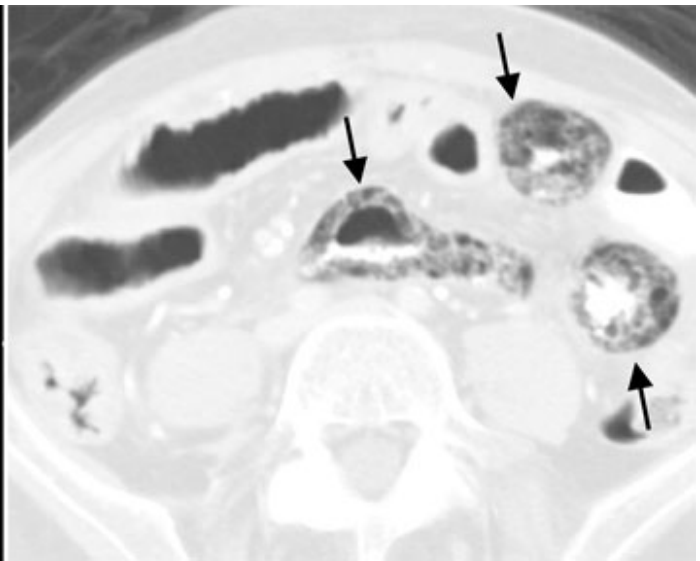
Contrast-enhanced CT scan in a patient with transmural small bowel infarction. Lung windows demonstrate multiple loops of small bowel with extensive gas within the bowel walls (pneumatosis).
